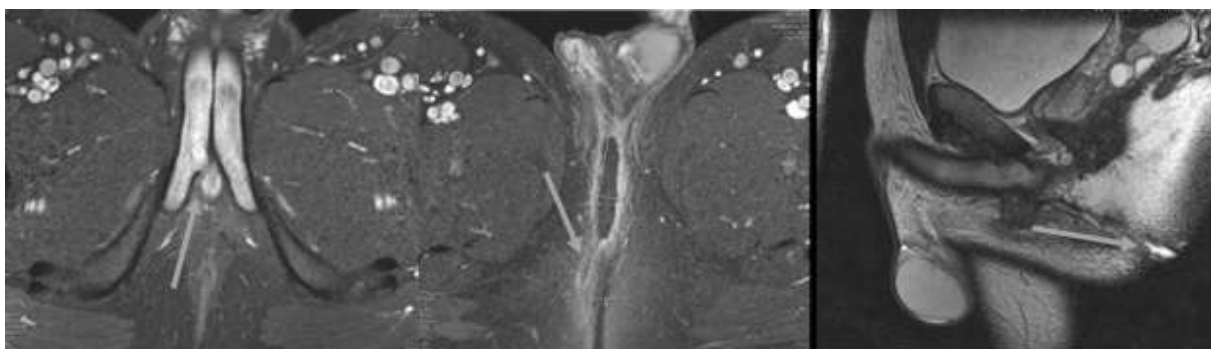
Pelvic MRI demonstrating extravasation from the corporal body along with the fistula tract to the perineum.
